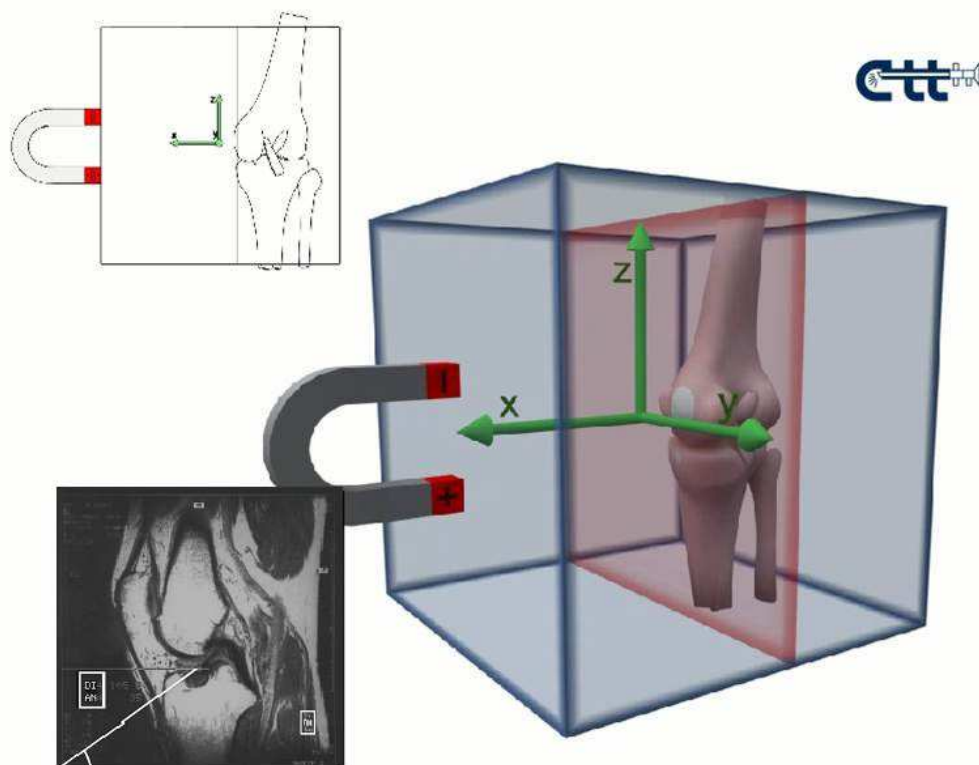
Three-dimensional coordinate axis created from the selected sagittal MRI image. Cubic initial space generated from the magnetic field from which the final sagittal MRI image is selected.
